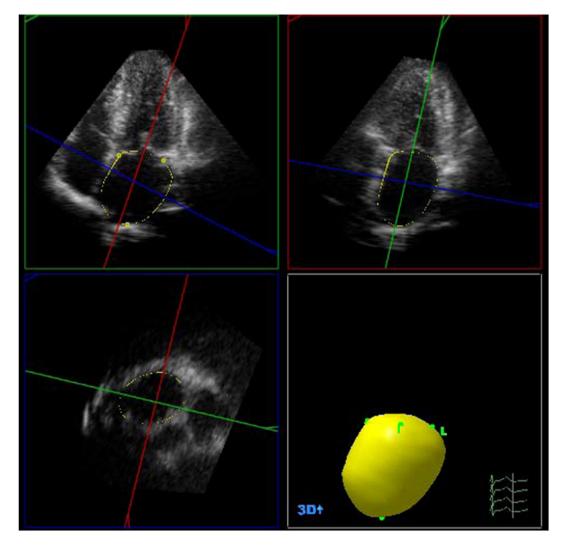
Calculation of LAV using RT3DE by automatic tracing using Q-lab software. Upper 2 images is apical 4-chamber and 2-chamber views, by marking 5 points, the whole LA cast was obtained.
